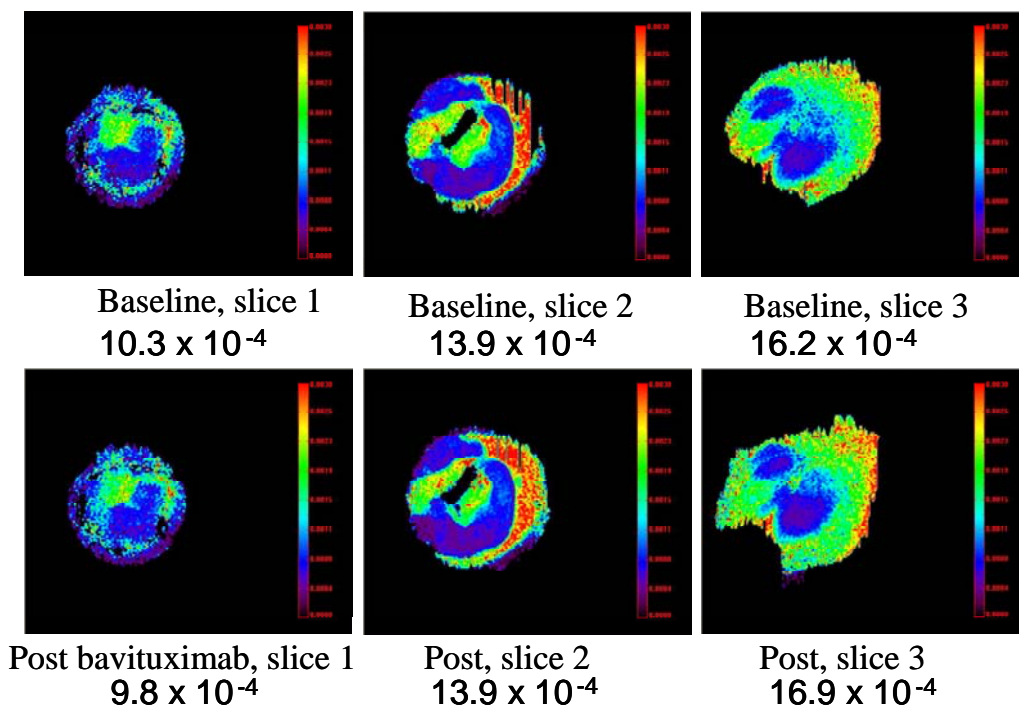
Apparent diffusion maps obtained by proton MRI at 4.7 T of Dunning prostate R3327-AT1 tumor. Data as for Figure 9, but showing three consecutive image slices in representative AT1 tumor. Distinct baseline heterogeneity is apparent with mean ADC ranging from 10.2×10^{-4} to 16.2×10^{-4} mm^2/s . The lower image shows the same slices 2 h after administration of 2.5 mg/kg bavituximab. There were no significant acute changes.
